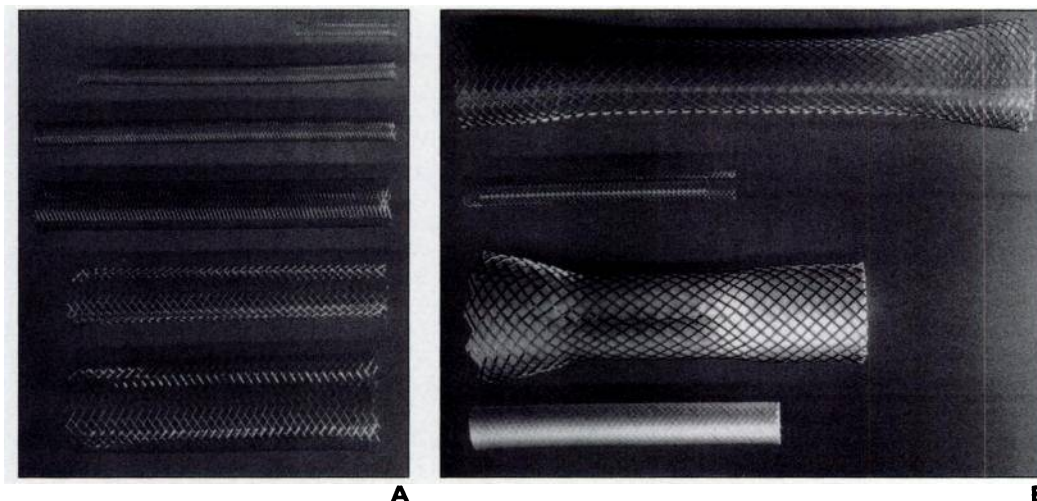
Photographs of metallic stents evaluated for safety during MR imaging. All stents were manufactured by Schneider, Minneapolis, MN. A, Names of stents shown in photograph from top to bottom: Wallstent Endoprosthesis (or Magic Wallstent), Iliac Wallstent Endoprosthesis, Iliac Wallstent Endoprosthesis, Iliac Wallstent Endoprosthesis, Tracheobronchial Wallstent Endoprosthesis, and Tracheobronchial Wallstent Endoprosthesis. B, Names of stents shown in photograph from top to bottom: Wallstent Esophageal II Endoprosthesis, Wallstent Endoprosthesis with permalume covering, Corvita Endoluminal Graft, and Iliac Wallgraft Endoprosthesis.
